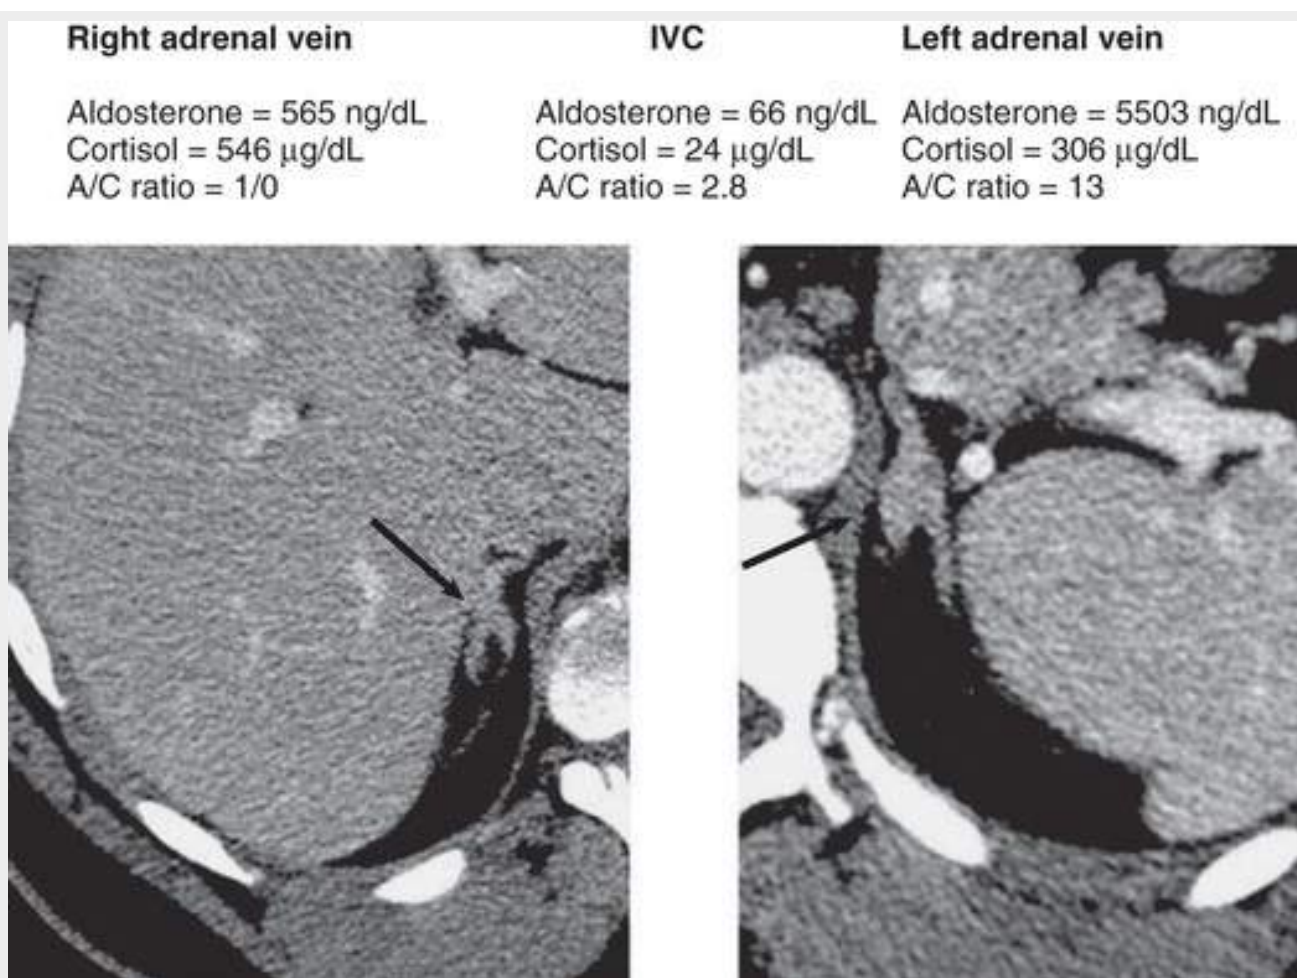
Computed tomography showing a left adrenal mass (*arrow*) and nodularity to the right adrenal gland. Adrenal vein sampling confirmed the diagnosis of a left aldosterone-producing adenoma. IVC, Inferior vena cava. (Case provided by Dr. Richard Auchus, Internal Medicine Department/Endocrinology Division, University of Michigan, Ann Arbor.)
